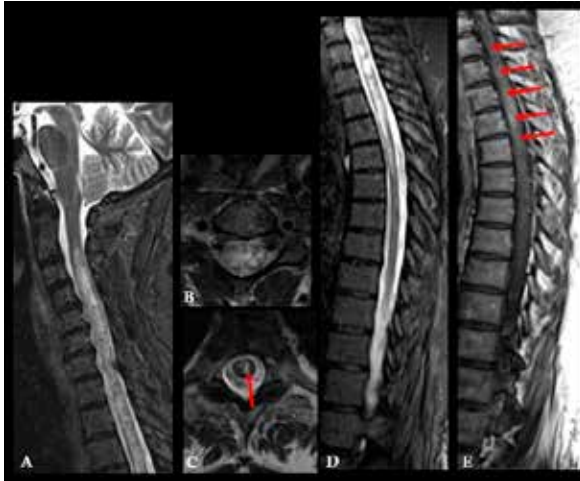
Longitudinally extensive transverse myelitis in an AQP4(+)/NMOSD 47-year-old female patient presenting with paraplegia. A long lesion extending from the cervical (A) to the upper thoracic cord (D) is demonstrated on sagittal STIR image. Axial T2-weighted images demonstrate the involvement of almost the entire cross-section of the cord (B) and a “bright spotty lesion” (arrow C). Lesion enhancement is also seen on sagittal T1-weighted contrast-enhanced images (arrows E).
